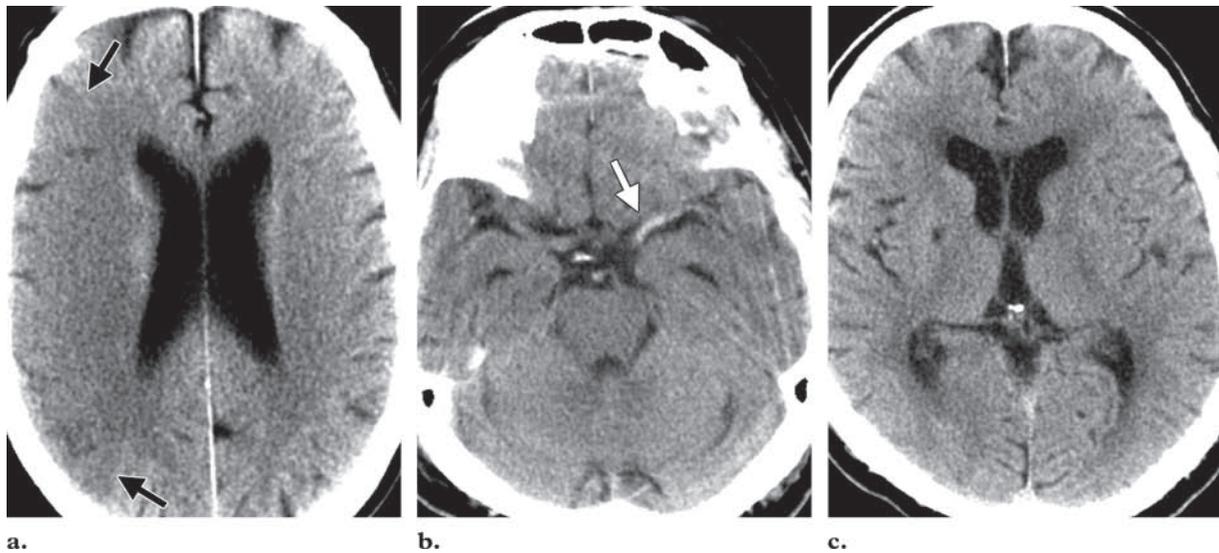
Early ischemic CT signs. CT scans show subtle hypoattenuation and sulcal effacement in the right MCA territory (arrows in a), a hyperattenuating left MCA (arrow in b), and obscuration and loss of gray matter–white matter differentiation of the left basal ganglia and sulcal effacement in the left MCA territory (c).
